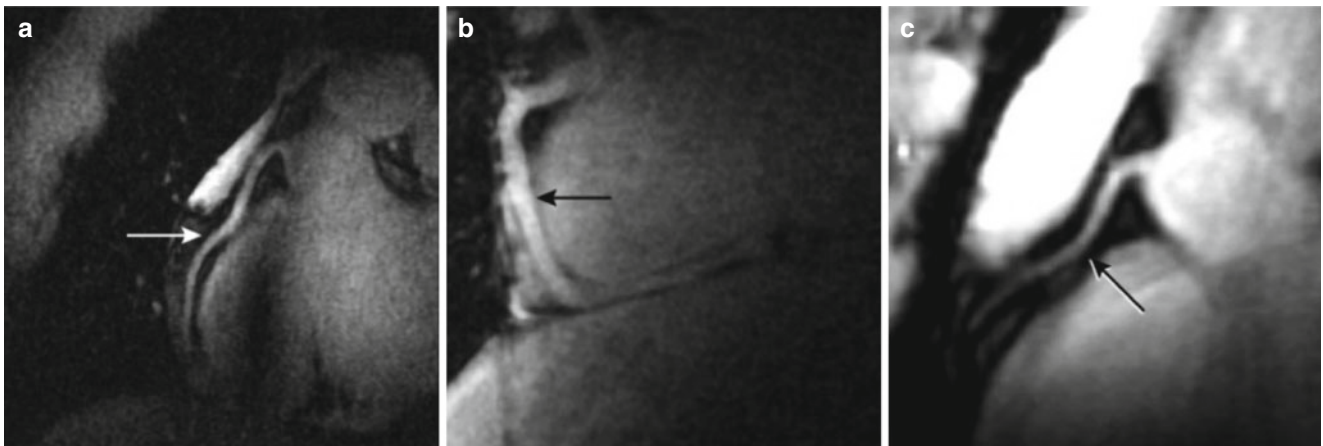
7T coronary MRI of the right coronary artery acquired using a gradient echo imaging sequence. Proximal (a, c) and more distal (b) segments of the RCA are visualized (arrows) (Adapted from Ref. [126], with permission of Wiley)
